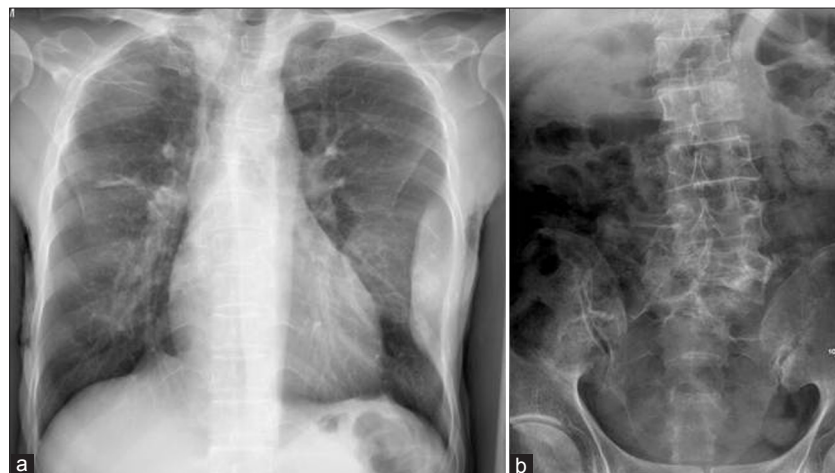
(a) Chest radiograph showing intrathoracic–extrapleural soft tissue mass involving the left seventh to tenth ribs. (b) Radiograph showing destruction in the L5 and S1 vertebrae
